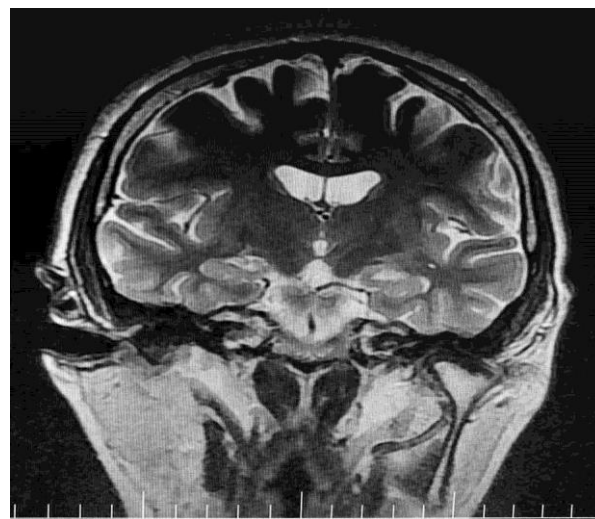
Coronal view of patient's brain magnetic resonance imaging (MRI)
